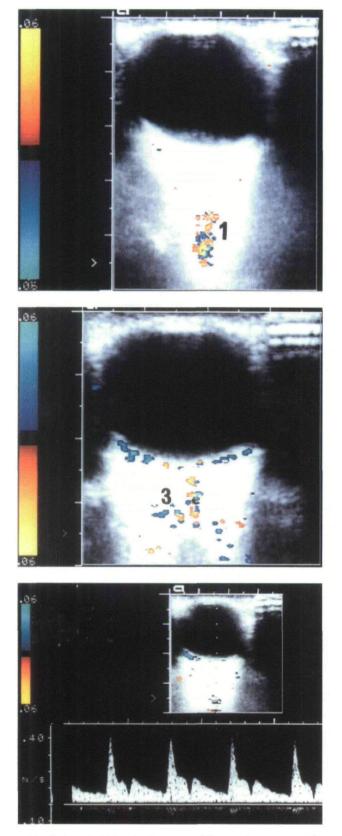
A typical Doppler frequency shift waveform recorded in this case from vessel 1. Maximum systolic velocity and minimum end diastolic velocity are easily measured, and resistive index calculated simply as described in the text.
